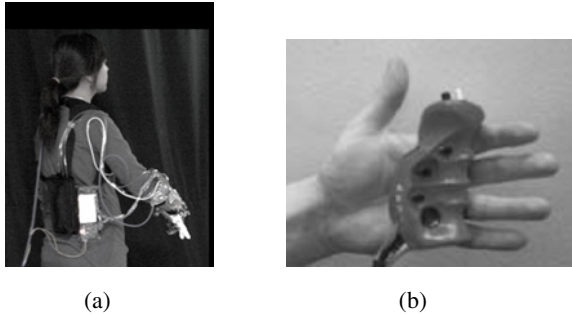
(a) Piezoelectric ultrasonic tactile display. (b) ARRL Interface.
